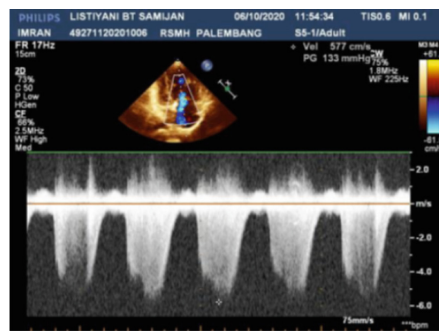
Echocardiography showed tricuspid regurgitation with pressure gradient 133 mmHg
